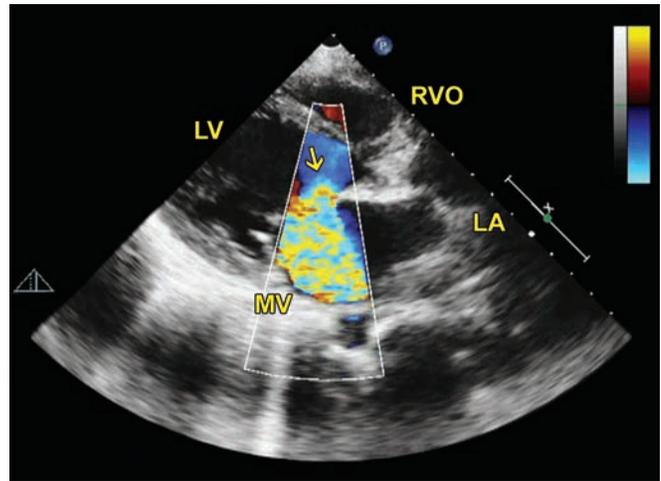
Color Doppler examination showing severe MR through the perforation (arrow) in the anterior MV leaflet.
